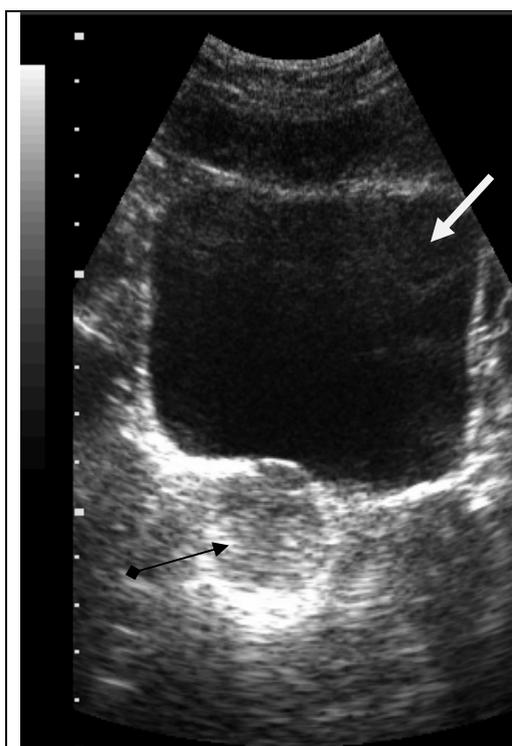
Ultrasonic of the urinary bladder
